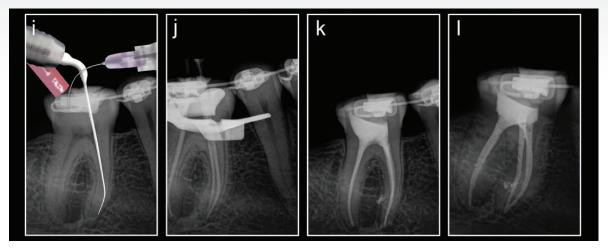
(i) Heated 3.5% sodium hypochlorite was dispensed continuously into the pulp chamber, and activated with the EDDY irrigating tip driven by a sonic air scaler. A suction tip was held next to the tooth to collect the excess spray and overflow from the pulp chamber; (j) Fit of TruNatomy gutta percha points confirmed radiographically; (k) Postoperative peri-apical radiograph after root canal obturation (parallel view). Note the maximum preservation of pericervical dentine; (l) Postoperative peri-apical radiograph after root canal obturation (mesial angulated view). Note the obturation of a midroot lateral canal
